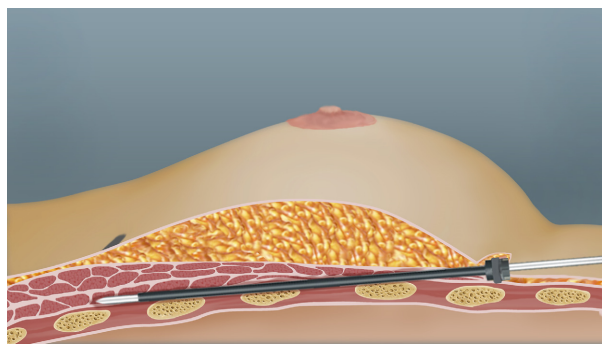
Subpectoral tunneling of the lead to reach the standard parasternal location.
